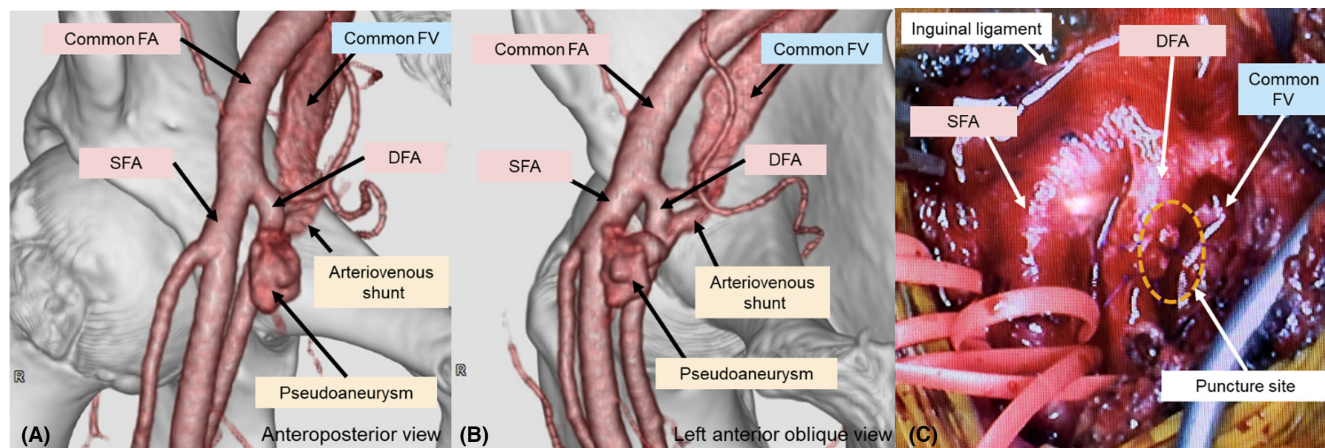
(A, B) The 3D CT imaging of the right groin (A: anteroposterior view, B: left anterior oblique view). Pseudoaneurysm arising from ventral surface of right DFA and arteriovenous shunt between right DFA and common FV were shown. (C) This intraoperative image of the right groin reveals that all three sheaths penetrate the DFA and are inserted into the common FV running directly below it. DFA, indicates deep femoral artery; FA, femoral artery; FV, femoral vein; and SFA, superficial femoral artery.
